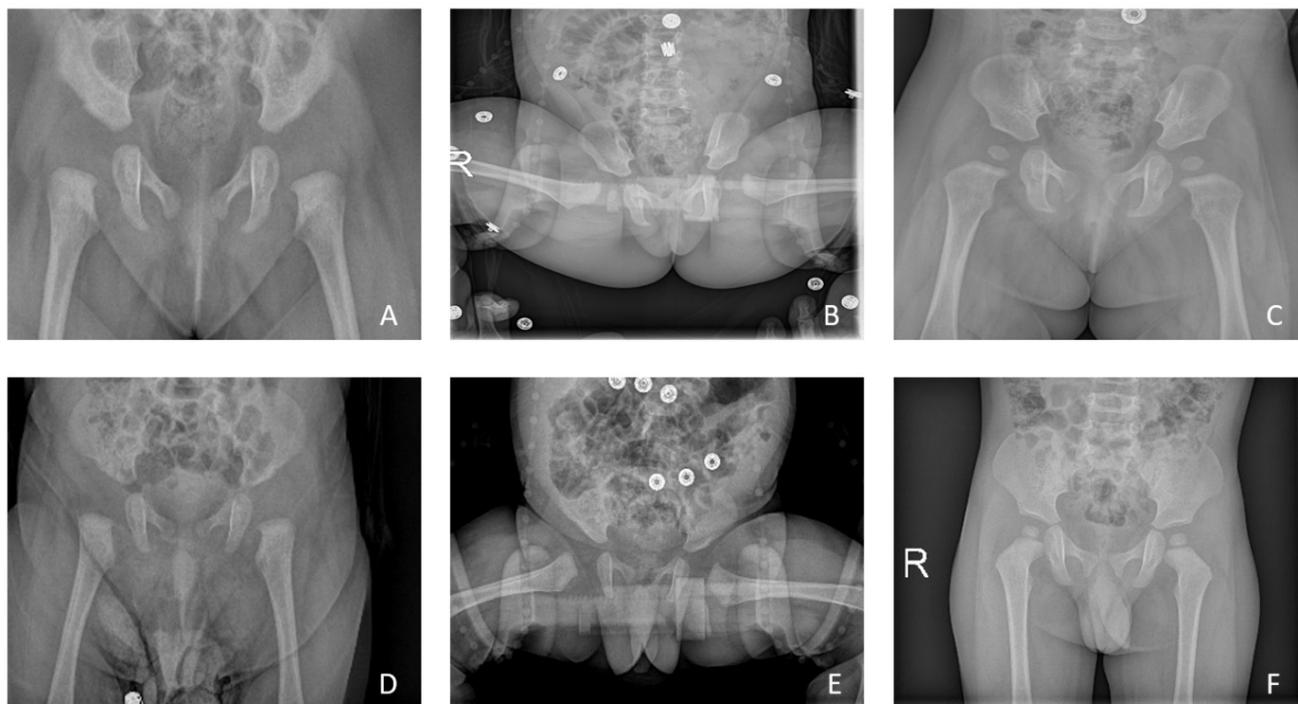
Case examples of this study. A) First hospital admission (4 months) radiography. B) After applying the Tubingen hip flexion-abduction splint. C) 9th-month control radiography. D) Another patient, first hospital admission (4 months) radiography. E) After applying the Tubingen hip flexion-abduction splint. F) 19th-month control radiography
